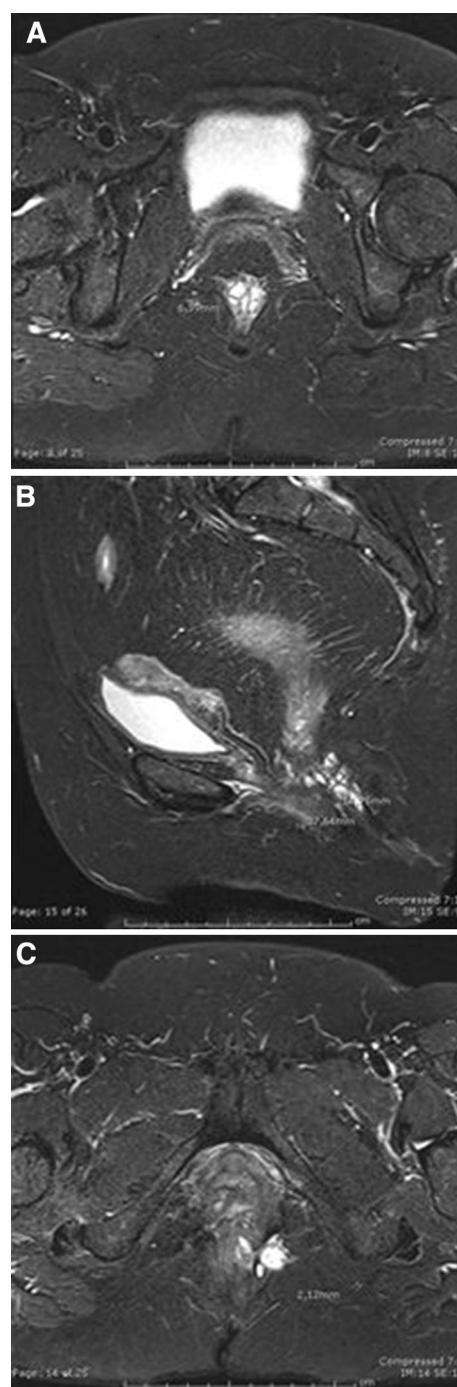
MRI images of a complex transsphincteric fistula; fat-saturated T2-weighted STIR sequences. A horseshoe collection is visible in the internal sphincter, thickness about 6 mm (a); it is situated anteriorly in the 9 to 4 o'clock position; from it an irregular, transsphincteric tortuous fistula tract arises with small communicating inter- and extrasphincteric fluid collections in an area ~3.7 cm long and 1.5 cm thick (b, sagittal projection); the tract is extended to the adipose tissue of the left ischiofemoral fossa traversing the fibers of the external sphincter to the left (c)
